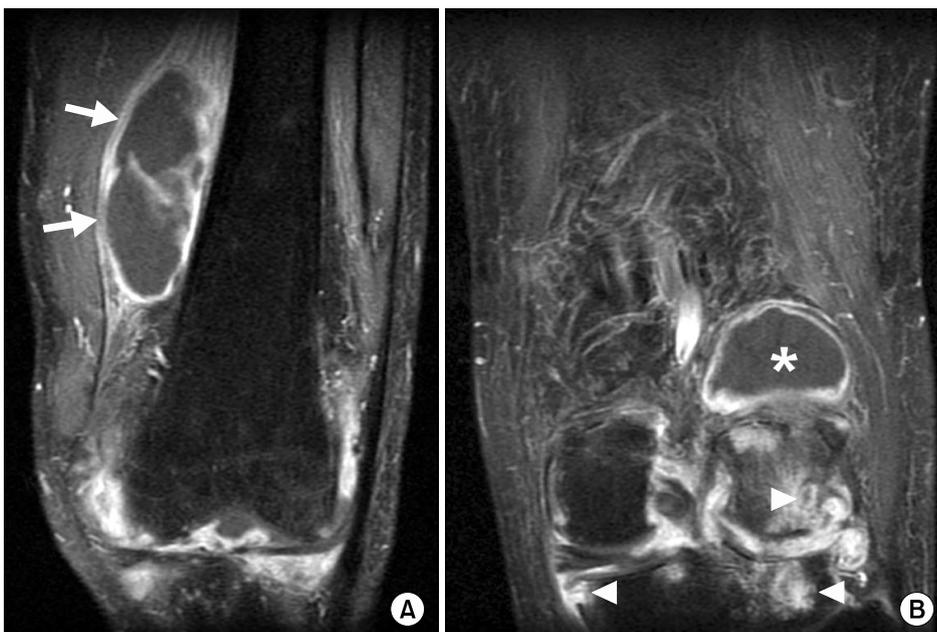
Gadolinium-enhanced coronal fat-suppressed T1-weighted magnetic resonance images show a peripherally enhancing fluid collection in the suprapatellar pouch (arrows) and lateral gastrocnemial bursa (asterisk). Note the intense enhancement of the synovium of the knee joint and bone erosions of the lateral femoral condyle and tibial plateau (arrowheads).
